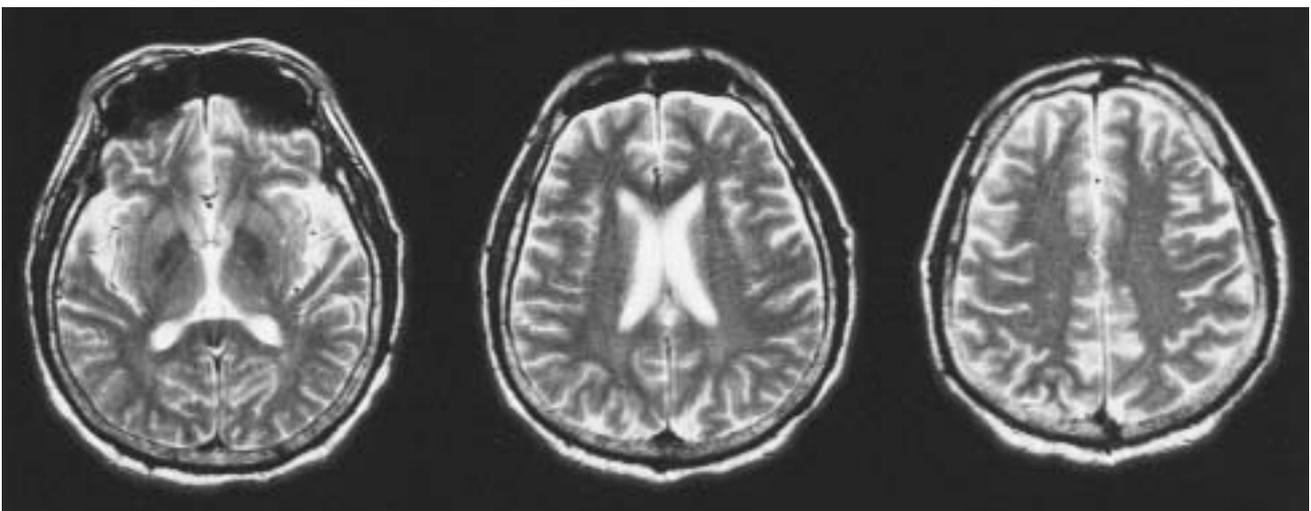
Brain MRI of patient 2 performed one week after the onset of symptoms revealed symmetric periventricular high signal areas and several small hyperintense lesions in the deep white matter of bilateral cerebral hemispheres, which might reflect nonspecific ischemic changes.
